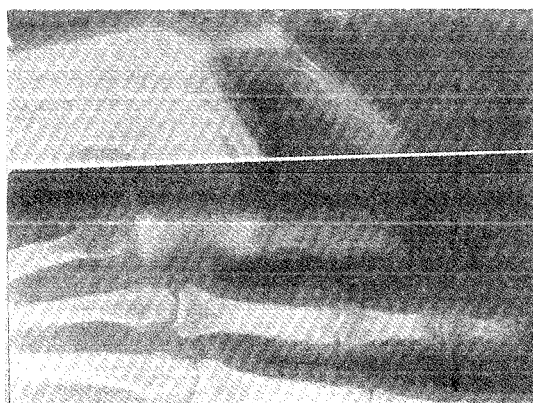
Post-operative x-rays of right little finger.
